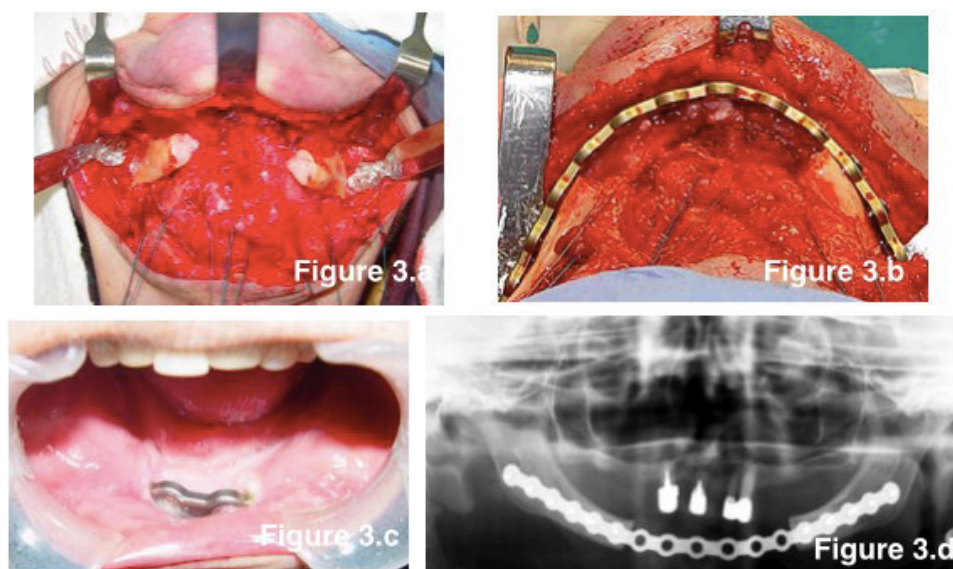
a) Resection of the necrotic bone; b) Reconstruction plate after bone debridement; c) Intraoral exposure of the plate; d) Immediate post-operative radiograph
